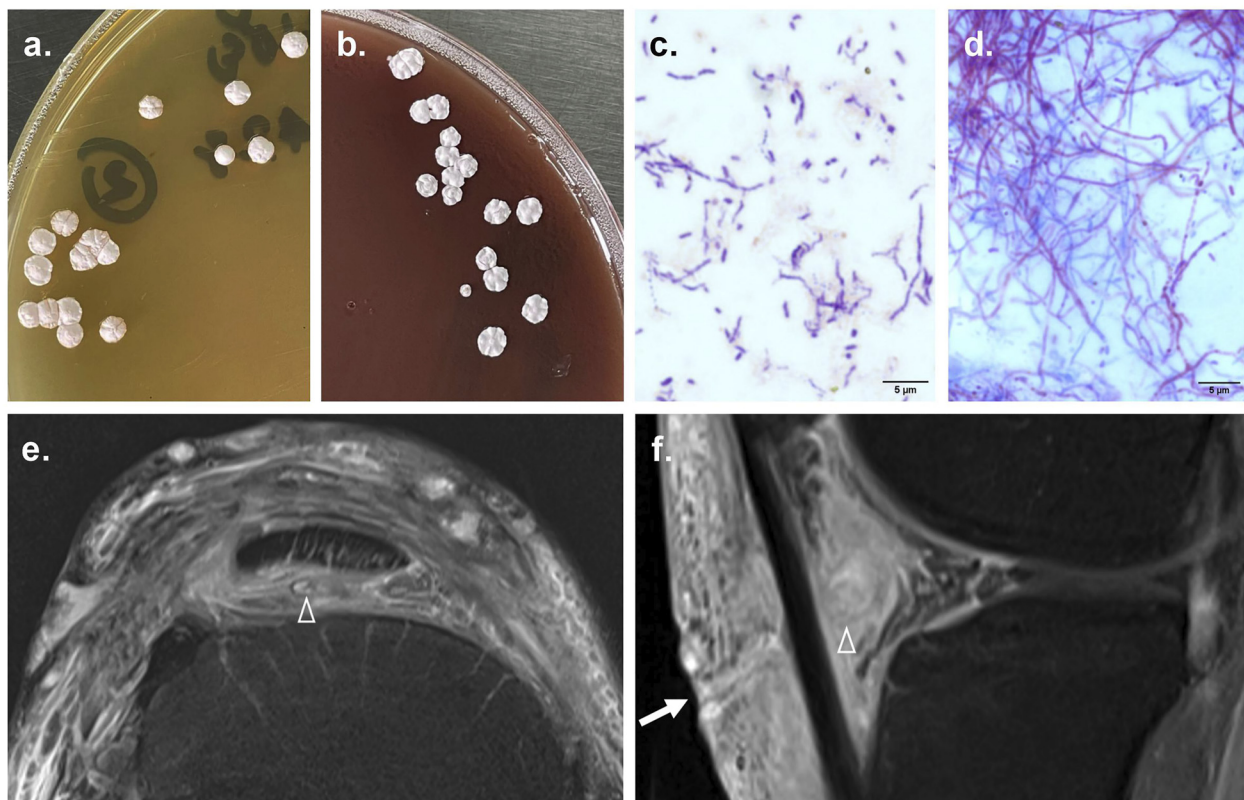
During the follow-up visit, the exudative cultures exhibited chalky white colonies on both International *Streptomyces* Project (ISP)-2 medium (a) and chocolate agar (b), with characteristic of Gram-positive (c) and partially acid-fast filamentous bacilli (d) (bar = 5 μm). Magnetic resonance imaging (MRI) findings of the knee on axial fat-suppressed T2-weighted image (e) and sagittal contrast-enhanced fat-suppressed T1-weighted image (f) show multiple small, round-to-oval hyperintense lesions separated by peripheral hypointense tissue in the skin and subcutaneous tissue, extending into the Hoffa fat pad. A lesion in the Hoffa fat pad contains a central hypointense dot, resulting in the 'dot-in-circle' sign (arrowhead). Surrounding hyperintense inflammatory changes are observed. There is a sinus tract in the infrapatellar region of the anterior knee, opening to the skin (arrow in Image f)
